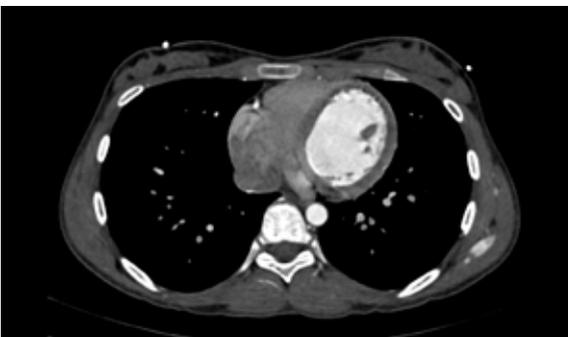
CARDIAC CT IMAGING SHOWING DILATED LV WITH THIN RIM OF SUBENDOCARDIAL HYPODENSITY.
